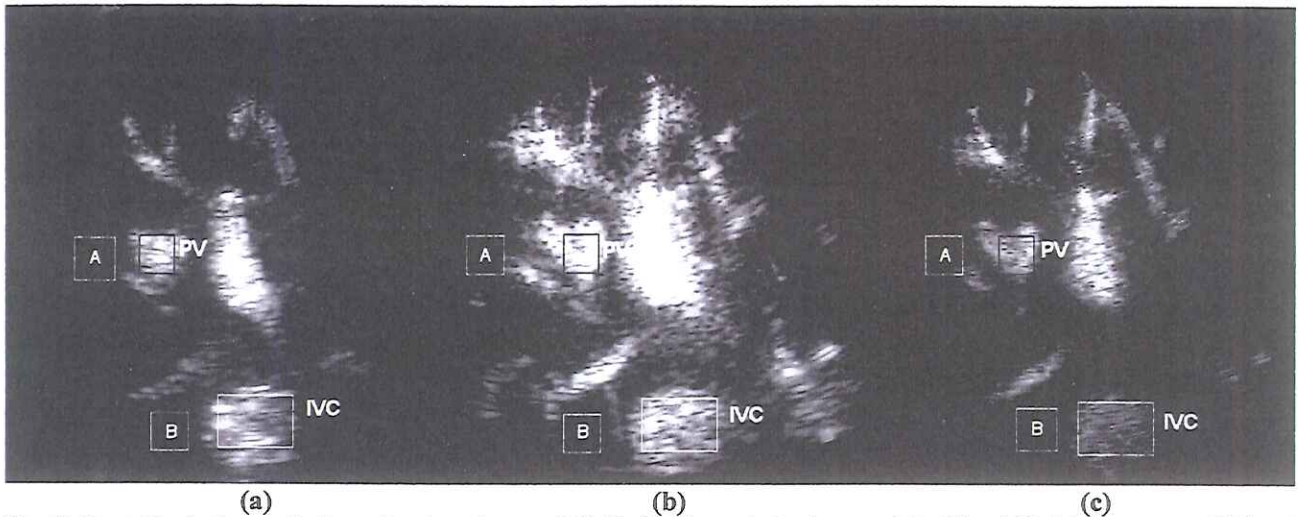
Power Doppler Images of a liver with a dynamic range of 30 dB. The four marked regions are clutter (A) and (B), inferior vena cava (IVC), and portal vein branch (PV). a) Conventional color Doppler without contrast at MI 1.2, b) Fundamental vascular flow with contrast at MI 0.07, c) Harmonic vascular flow with contrast at MI 0.07.
